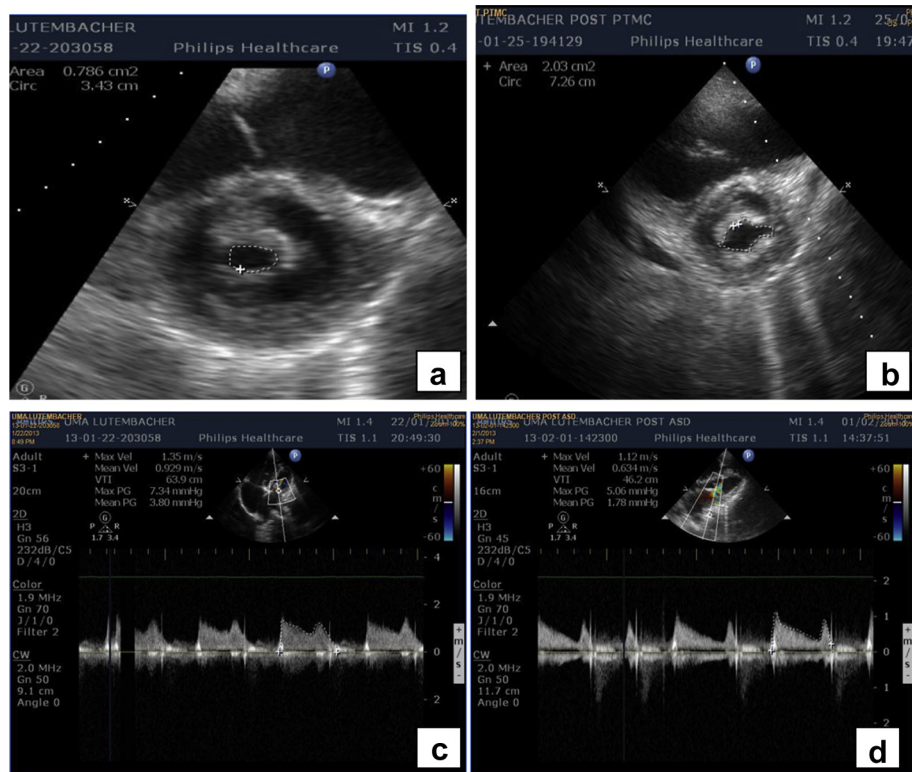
a and b) Parasternal short axis on TTE pre and post PTMC respectively. (c and d) CW Doppler across MV pre and post PTMC respectively.
